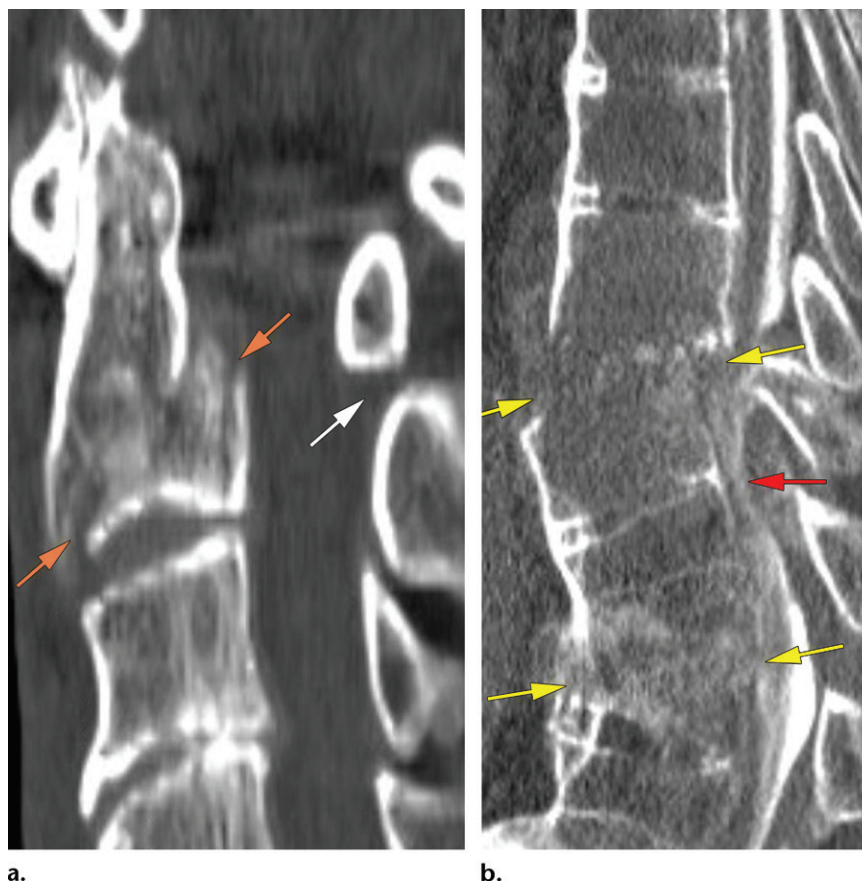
Neurologic deterioration in an 81-year-old man with AS who presented with headache and neck pain after falling. (a) Sagittal CT image of the cervical spine obtained on April 4 shows a comminuted fracture (orange arrows) of C2 at the base of the dens, with an 8-mm anterior translation of C1 on C2 (white arrow). No additional imaging was performed, and the patient was released in a C-spine hard collar. On April 18, he presented with confusion and new-onset weakness in the left lower extremity. The patient's weakness quickly progressed to bilateral lower extremity weakness the following day. (b) Sagittal CT myelogram shows a T9-T10 hyperextension-translation injury (yellow arrows) with severe canal narrowing and cord compression, findings suggestive of an extensive epidural hematoma (red arrow). Of note, MRI could not be performed owing to the presence of a pacemaker.
